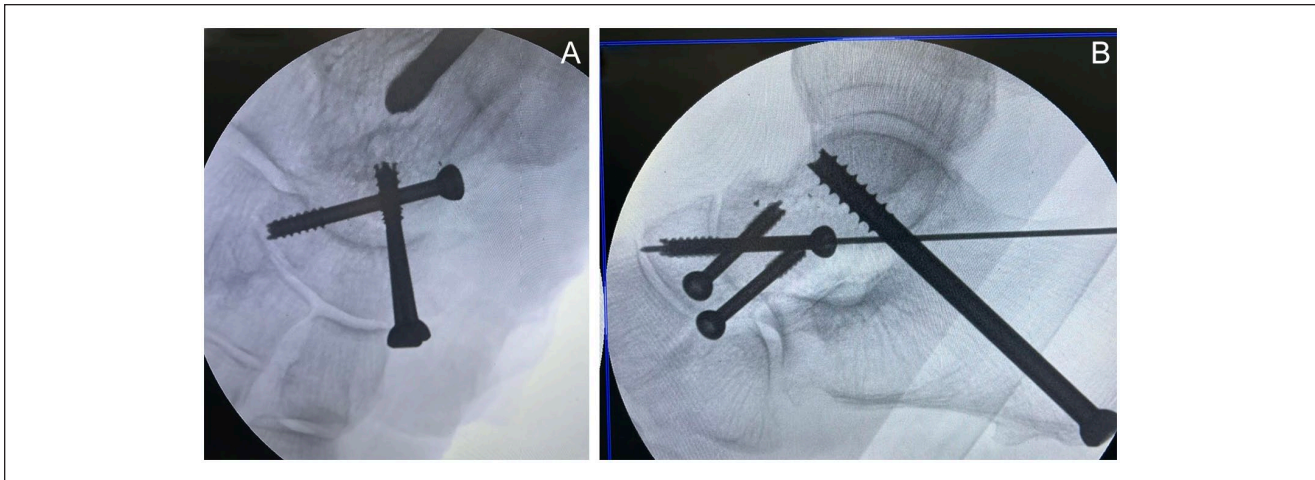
Transoperative (A) anteroposterior and (B) lateral radiographs of lateral joint fixation after cannulated screw fixation.
